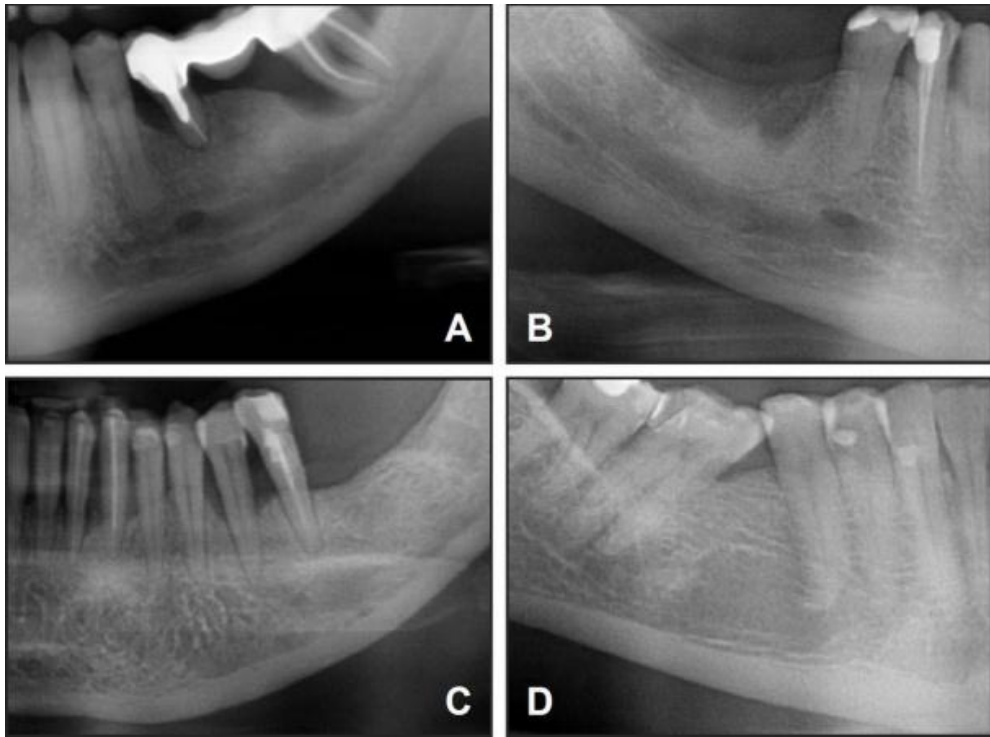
The appearance of the mental foramen on panoramic radiographs. A = continuous; B = separated; C = diffuse; D = unidentified type (*Juodzbaly et al., 2010*).
